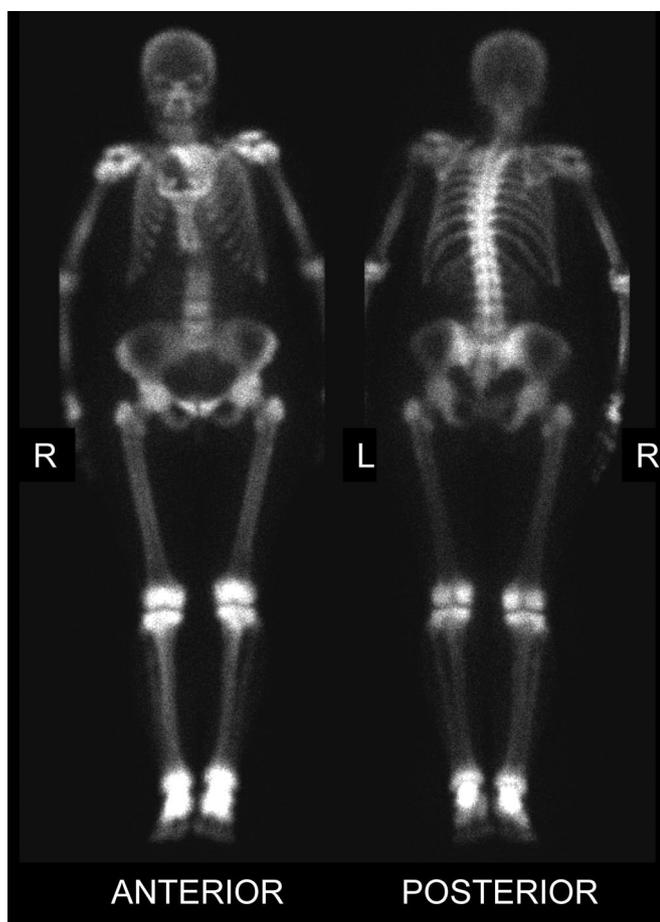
Whole-body bone scintigraphy demonstrates diffusely increased radionuclide uptake in the axial and appendicular skeleton, with more focal periarticular activity in the knees and ankles, and minimal to absent activity in the soft tissues and kidneys. These findings are suggestive of metabolic bone disease and would be consistent with SF.
